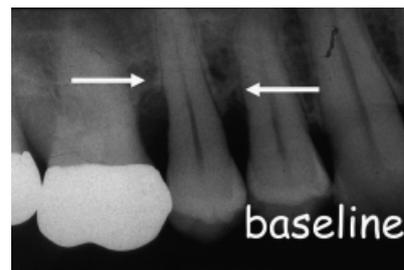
Pre-operative X-ray of the intra-bony defect.
